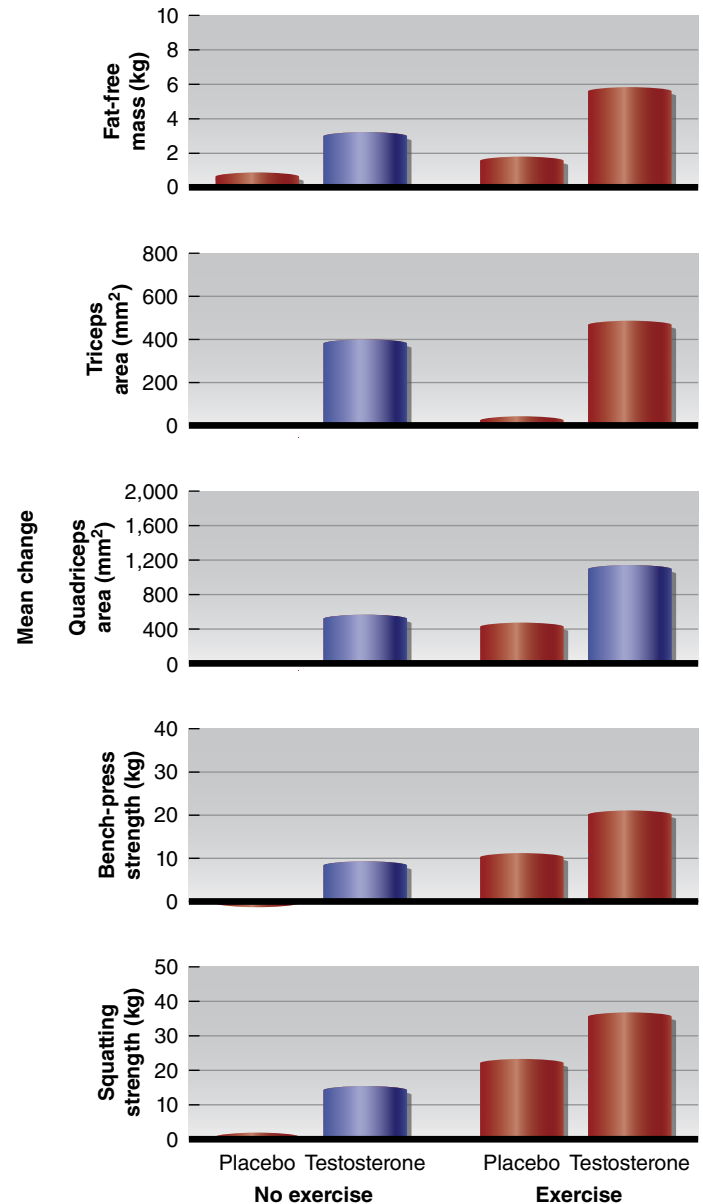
Changes in fat-free mass and quadriceps and triceps muscle areas from magnetic resonance imaging, and changes in squat and bench press strength over 10 weeks of placebo or testosterone, with or without exercise training.
